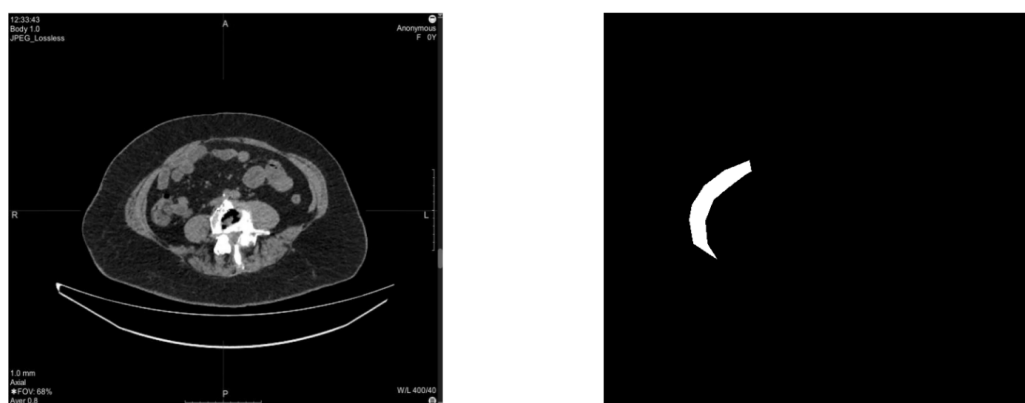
An example of a CT scan and the corresponding mask of the musculo-aponeurotic layer of the anterior abdominal wall on the right
